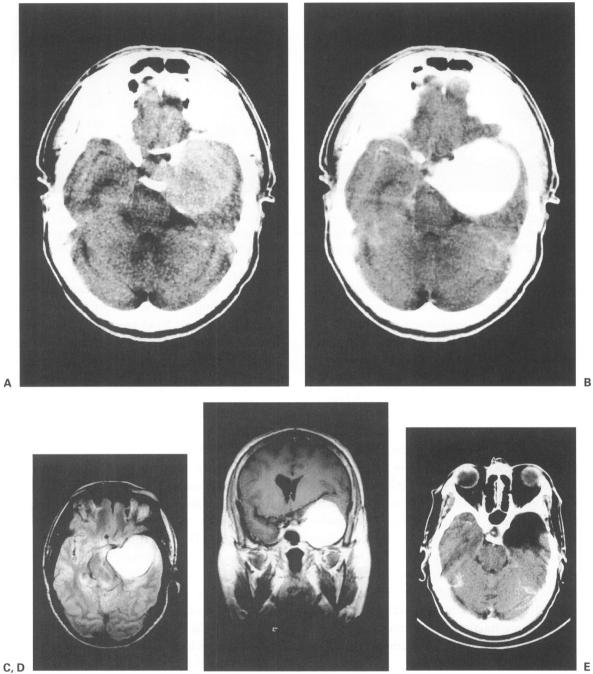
(A) Transverse unenhanced and (B) contrast-enhanced CT scans. The left parasellar mass lesion is spontaneously hyperdense compared with the brain parenchyma. After intravenous contrast injection, it enhances markedly and homogeneously. The (C) transverse unenhanced proton density-weighted fast spin-echo and (D) coronal gadolinium enhanced T1-weighted spin-echo images provide more accurate delineation of the lesion and suggest an extra-axial topography. (E) Postoperative transverse contrast-enhanced CT image shows that the lesion has been resected totally.
